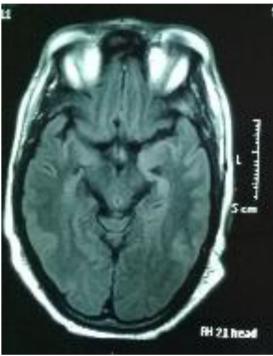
(a) and (b) Cerebral MRI (T2 + FLAIR) shows no abnormal signal within the limbic regions.
